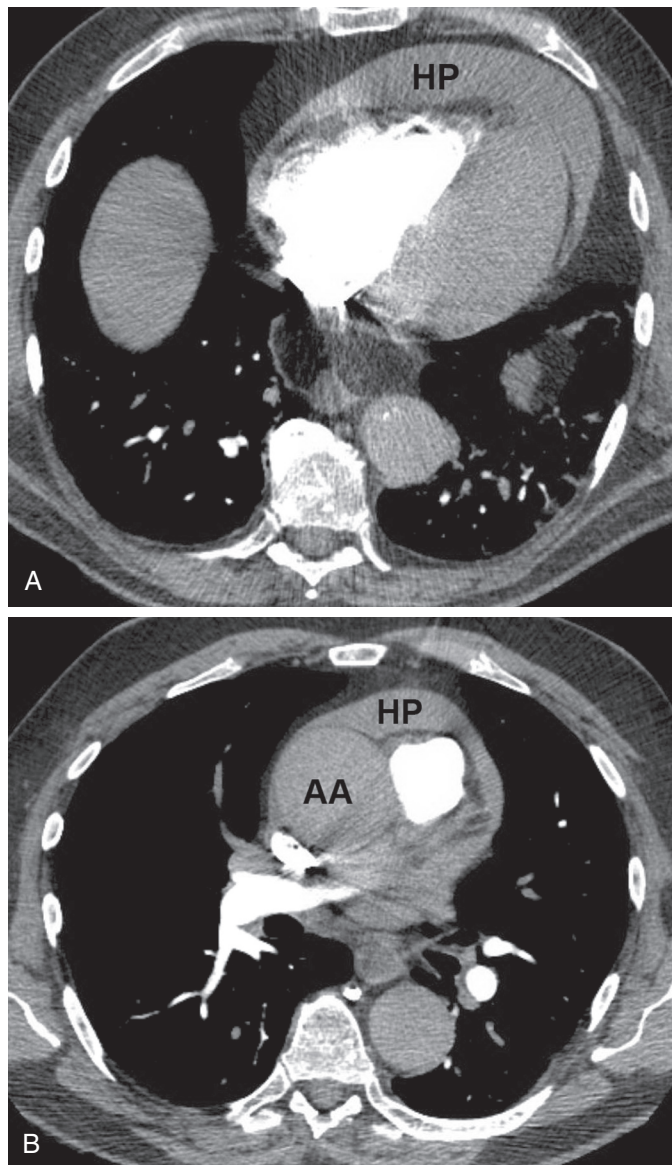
■ A, Axial computed tomography (CT) slice. Large pericardial hematoma (HP) with narrowing of the right ventricle and straightening of the interventricular septum, findings of associated cardiac tamponade. B, Axial computed tomography (CT) slice. Etiology of the same patient's hemopericardium (HP) and cardiac tamponade is a "leaking or ruptured" ascending aorta aneurysm (AA).
